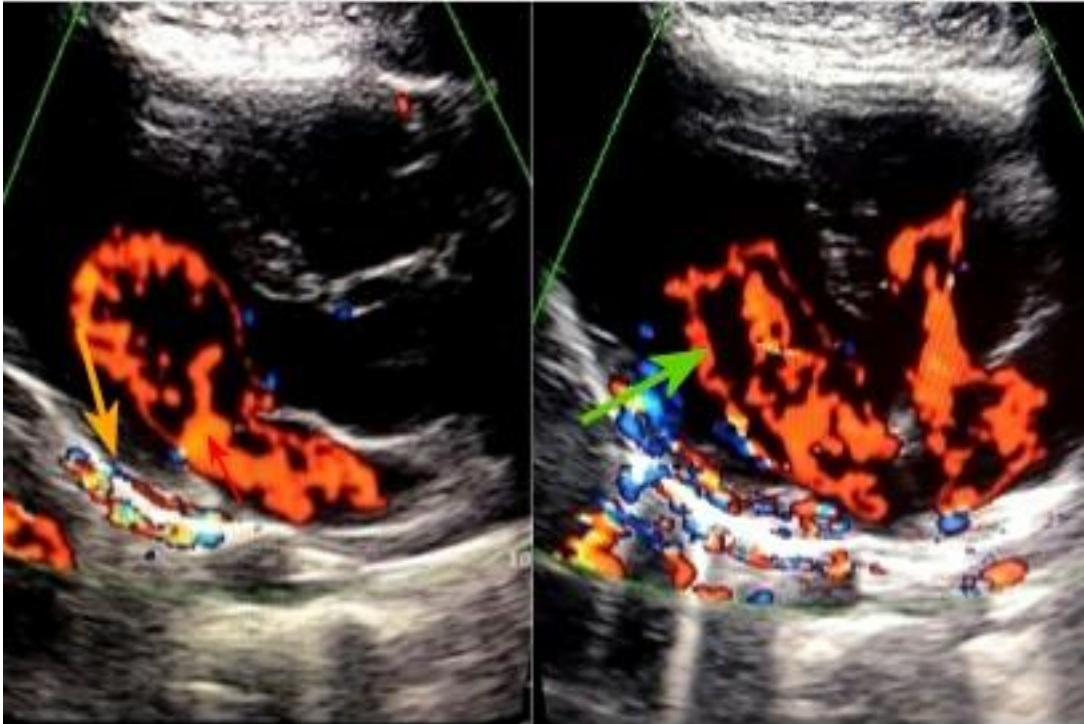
Long parasternal and Modified views; show the coronary arteries of the related walls left & both ventricles respectively, in addition to the small network arteries (red arrow), Stenosis (yellow arrow), dilated pre-stenotic segment (green arrow), & the blue vessel segments.
